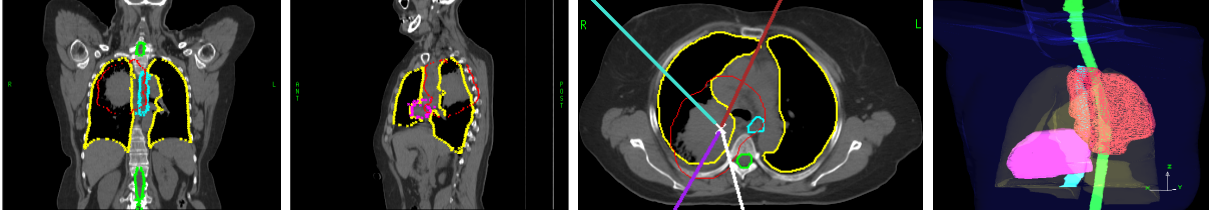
The left three panels show CT image slices in the treatment plane for patient #8 in our study; the rightmost panel shows a beam’s eye view of the same case. The PTV is shown in red, the lungs in yellow, the spinal cord in green, the heart in pink, and the esophagus in cyan. The solid lines in the third panel show the beam directions.
